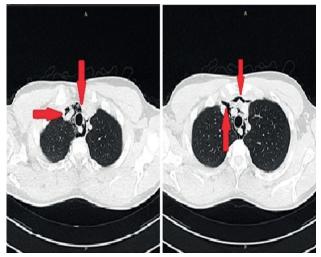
Computed tomography of the chest indicating pneumomediastinum (red arrows)
